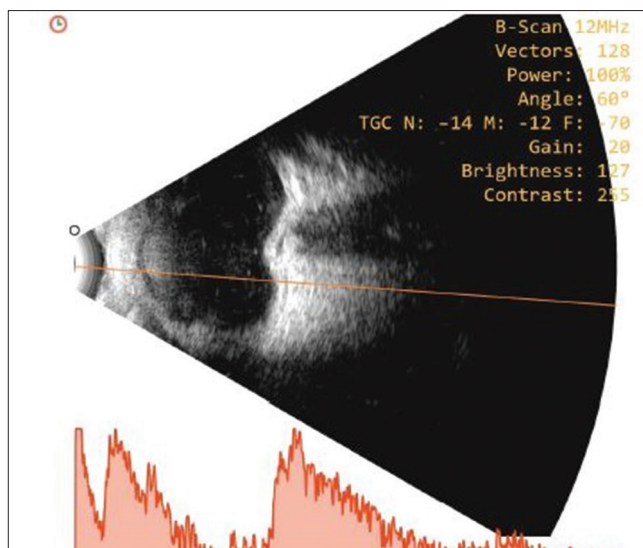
Ultrasound B scan with A scan vector image showing attached retina with posterior globe indentation. A hyporeflective space outside the ocular coats adjacent to ONH shadow causing retino-choroidal elevation suggestive of posteriorly migrated scleral buckle
